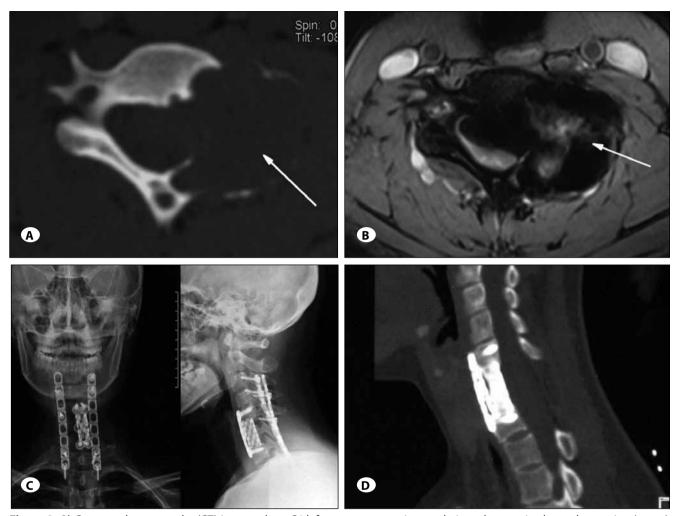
A) Computed tomography (CT) images show C6 left accessory-centric osteolytic and expansive bone destruction (arrow). B) Magnetic resonance imaging showed a low-intensity signal with patchy high-density signals on the T2-weighted images; the spinal cord was severely compressed (arrow). C) Postoperative antero-posterior and lateral plain graphs showed the internal fixation positioning. D) CT image taken 6 years after surgery showed no recurrence.
